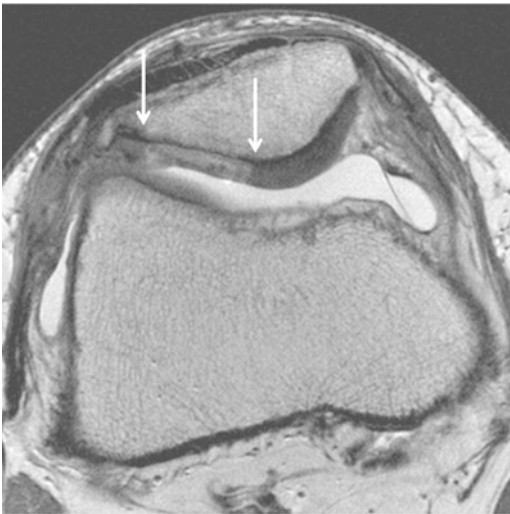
Conventional axial proton-density-weighted (PDW) high-resolution turbo-spin-echo (TSE) MRI of a 30-year-old female patient at early follow-up of 3 months after matrix-associated chondrocyte transplantation. The arrows show inhomogeneous MR signal intensity of the repair tissue matrix. (Acquisition parameters: TR: 2400 ms; TE: 28 ms; flip angle: 160°; in-plane resolution: 0.23 × 0.23 mm; matrix: 512 × 512; slice thickness: 2 mm; slices: 34; TA: 6:01 min)
